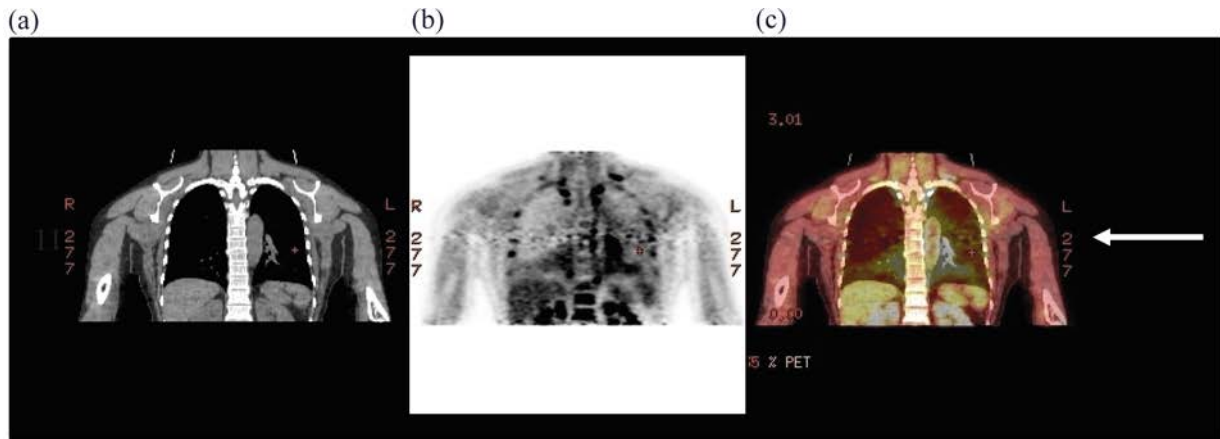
Coronal CT (a), AC-PET (b) and fused AC-PET/CT (c). The arrow points to the area of increased noise level in the bed overlap region. AC: attenuation corrected.
